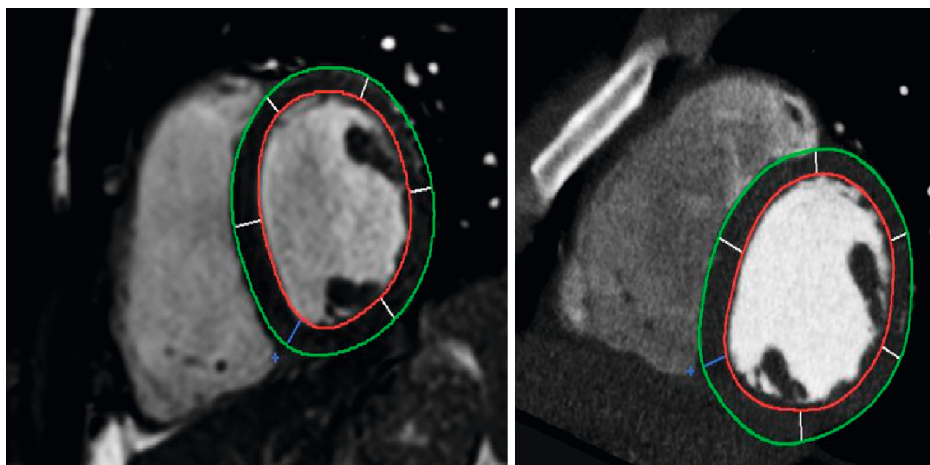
Example of LV segmentation of a middle region slice of the same patient for both cardiac MRI (left panel) and CCTA (right panel). The red lines represent the endocardial contours. The green lines represent the epicardial contours. The reference point is marked by the small blue cross. Middle region wall thickness for this patient was 8 mm on MRI and 6 mm on CCTA.
